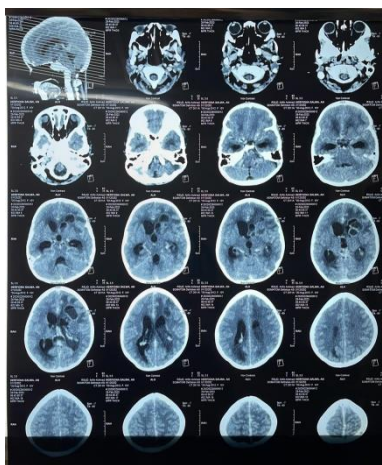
CT scan of the head
